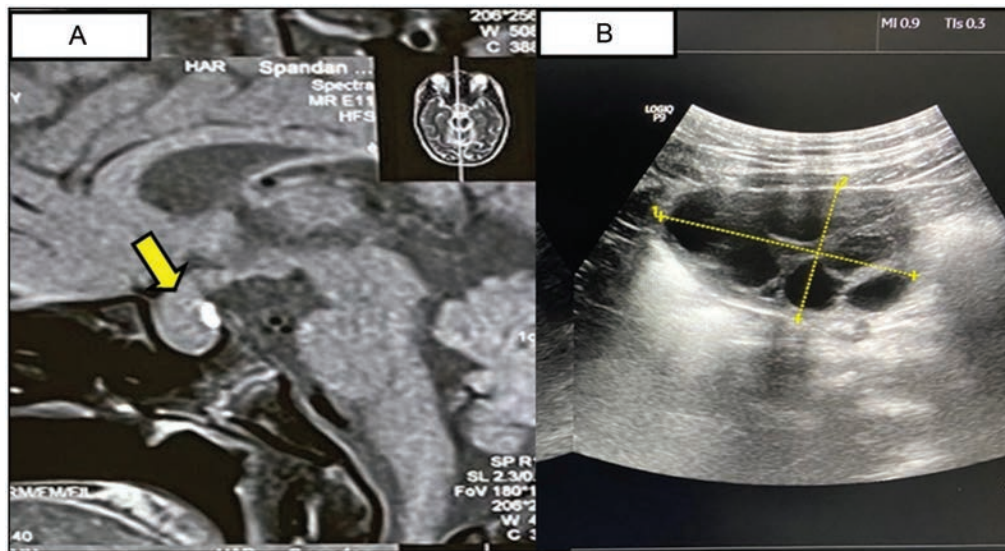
(A) T1 weighted MRI pituitary showing diffusely enlarged pituitary due to thyrolactroph hyperplasia. (B) USG pelvis showing large multicystic right ovary (volume: 66.82mL)
